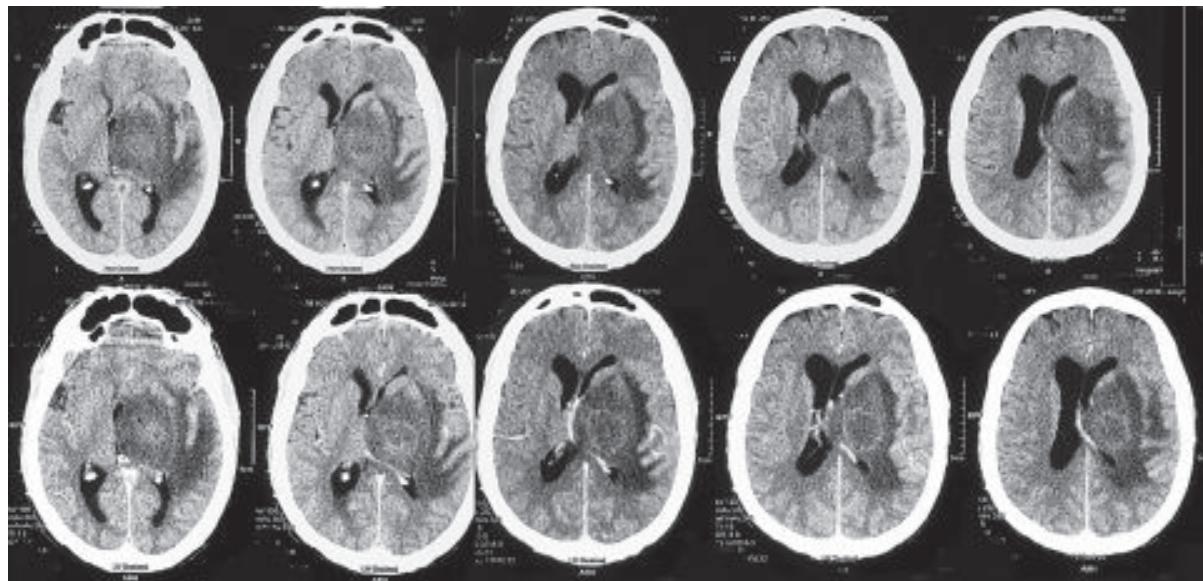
CT scan of brain of the patient. Upper row showing non-contrast image and lower row showing post contrast image.
